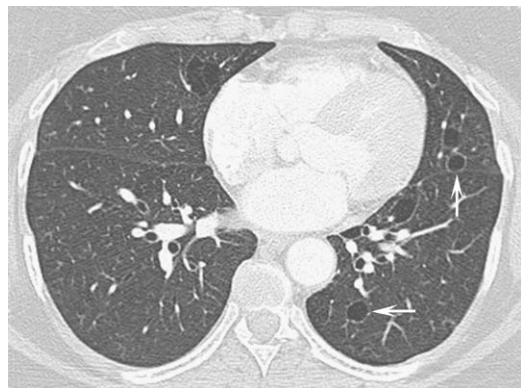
Cystic pulmonary disease: lymphocytic interstitial pneumonia. Axial HRCT image through the lower lobes shows multiple thin-walled cysts (arrows) in a patient with Sjögren’s syndrome.
